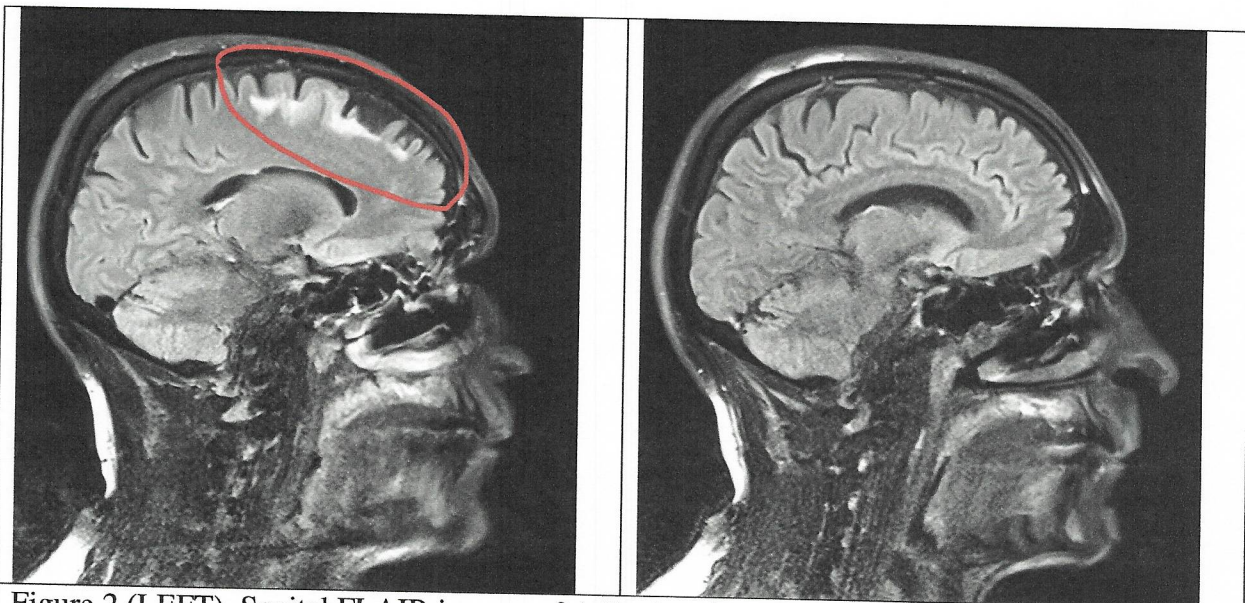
(LEFT). Sagittal FLAIR images of A.D. showing encephalomalacia and glial scarring in left dorsomedial prefrontal cortex (dmPFC) . (RIGHT) Undamaged right frontal lobe from same sequence.
